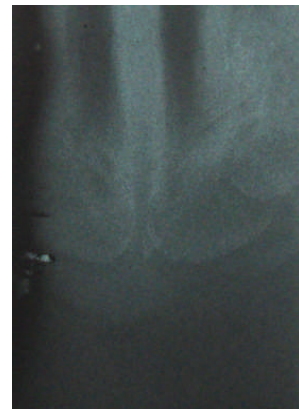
Radiograph of palate of a fetus aged 24 weeks after conception.
